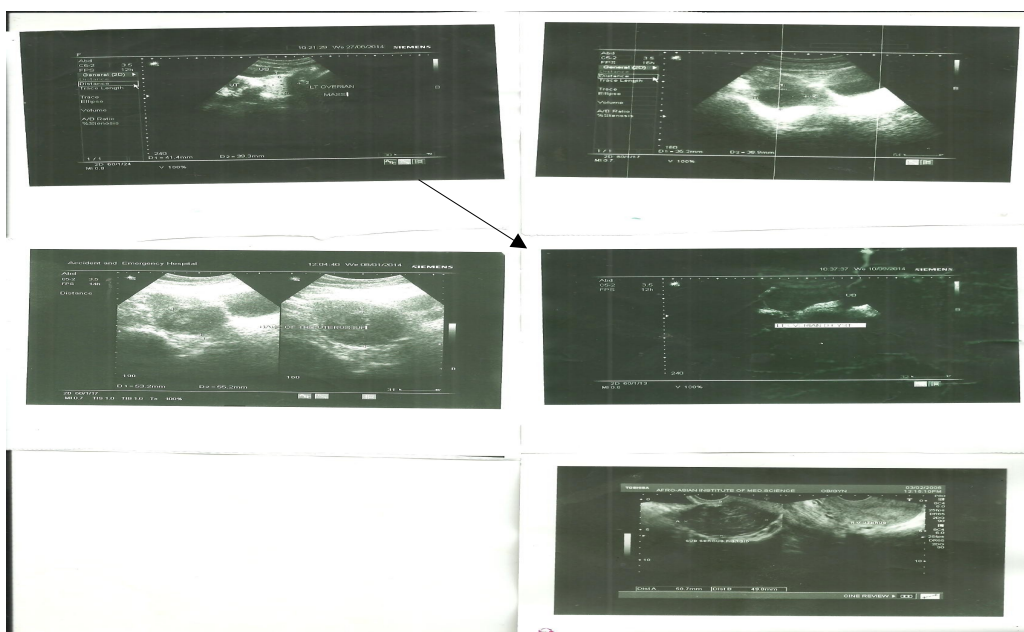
Figure nine: 32 old Ultrasound show ovarien mass
